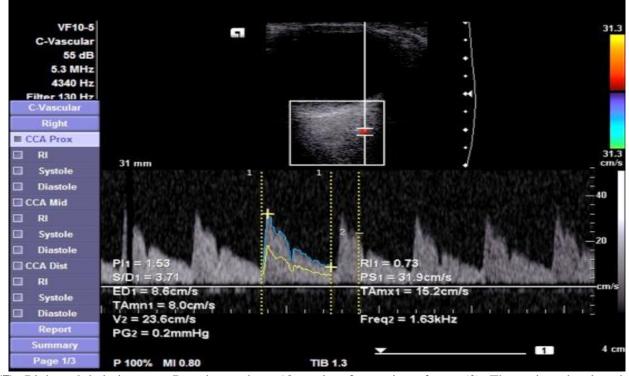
Right ophthalmic artery Doppler study at 10 weeks of gestation of case (3). The patient developed severe preeclampsia on follow up
